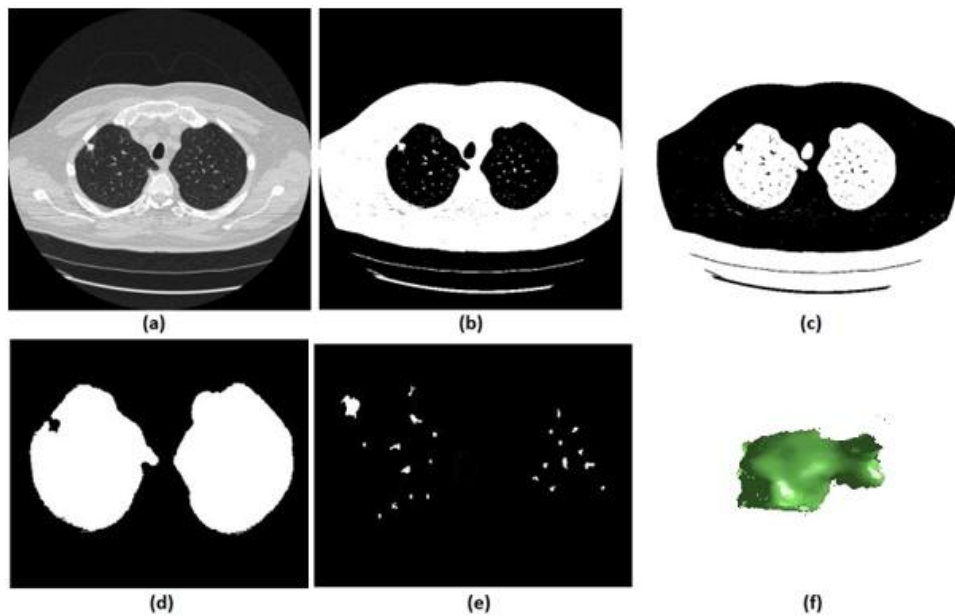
(a) Original CT 2-D slice, (b) cluster-2 seed mask, (c) cluster-1 seed mask, (d) Lung mask with juxta nodule hole, (e) Segmented nodule candidates, (f) 3-D visualization of one segmented nodule.
